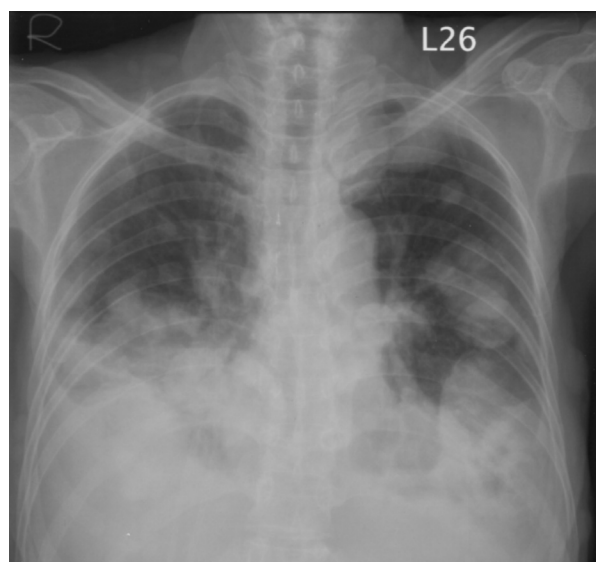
Chest X-ray shows bilateral multiple lung nodules with pleural effusion.
